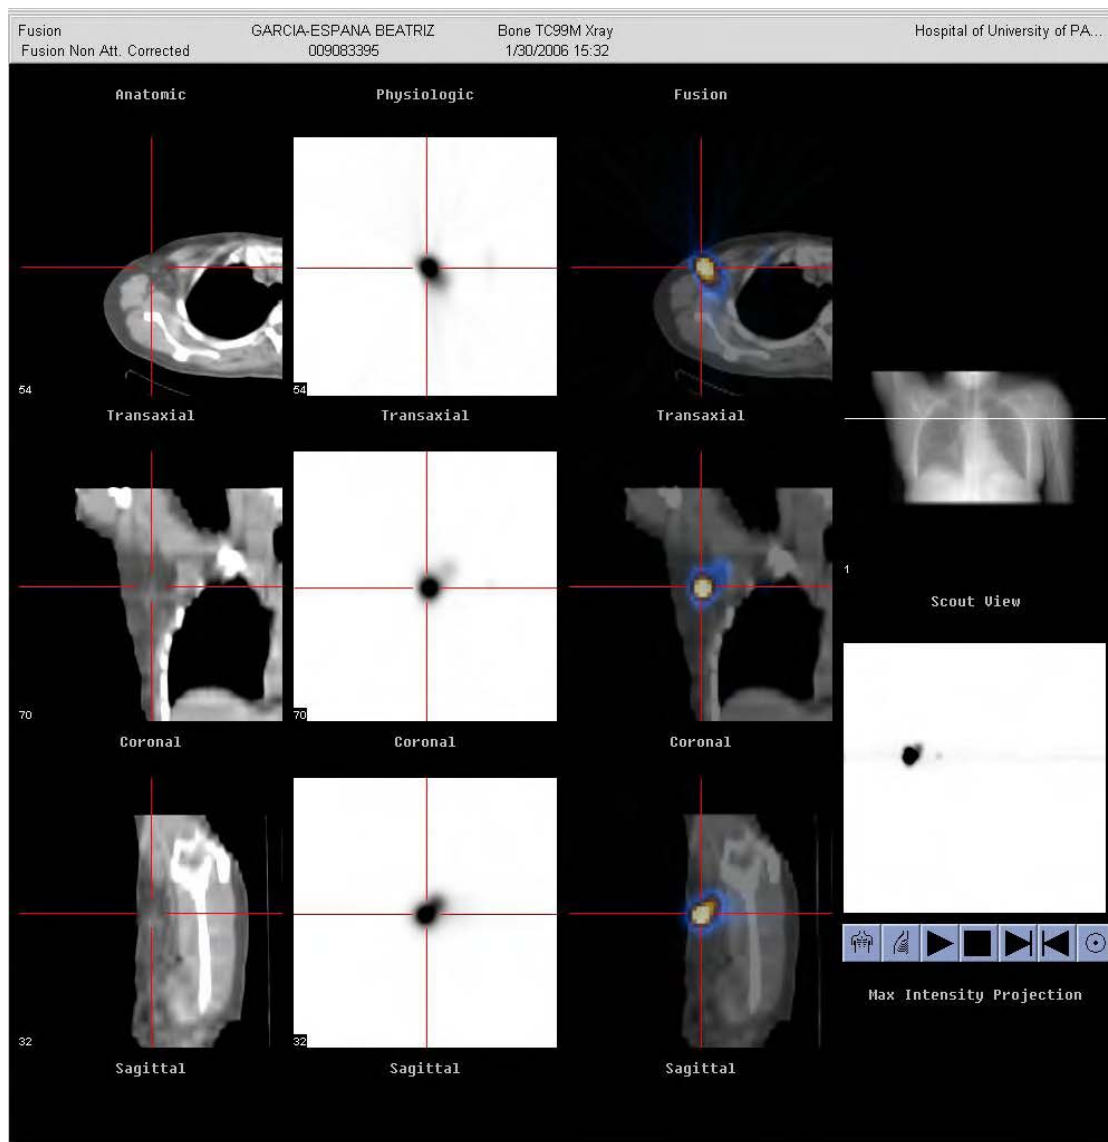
SPECT/CT images in transaxial, coronal, and sagittal planes of a breast cancer patient status post lumpectomy and SNLB with 2 visible LNs in the lateral axilla
